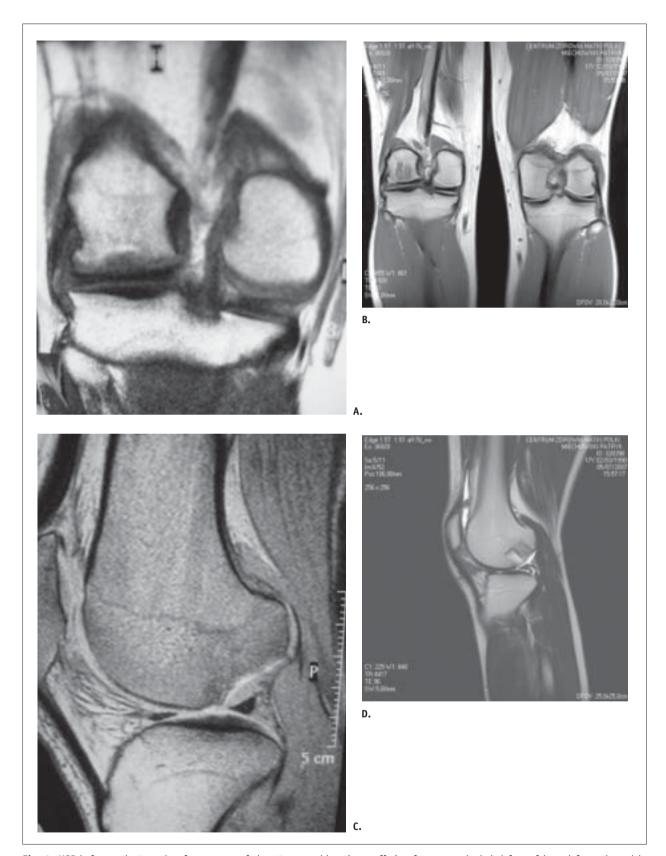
MRI before and 12 weeks after surgery of the 17 years old patient suffering from osteochodral defect of lateral femoral condyle of right knee. A. Coronal section of right knee before surgery – large osteochondral defect of lateral femoral condyle. B. Sagittal section of right knee before surgery – large osteochondral defect of lateral femoral condyle. C. Coronal section of right and healthy left knees 12 weeks after surgery – good osteointegration of the grafts, partial remodeling and relatively good congruence of joint line with signal of neocartilago in comparison to contralteral knee. D. Sagittal section of right knee – g.ood osteointegration of the grafts, partial remodeling and relatively good congruence of joint line with signal of neocartilago.
